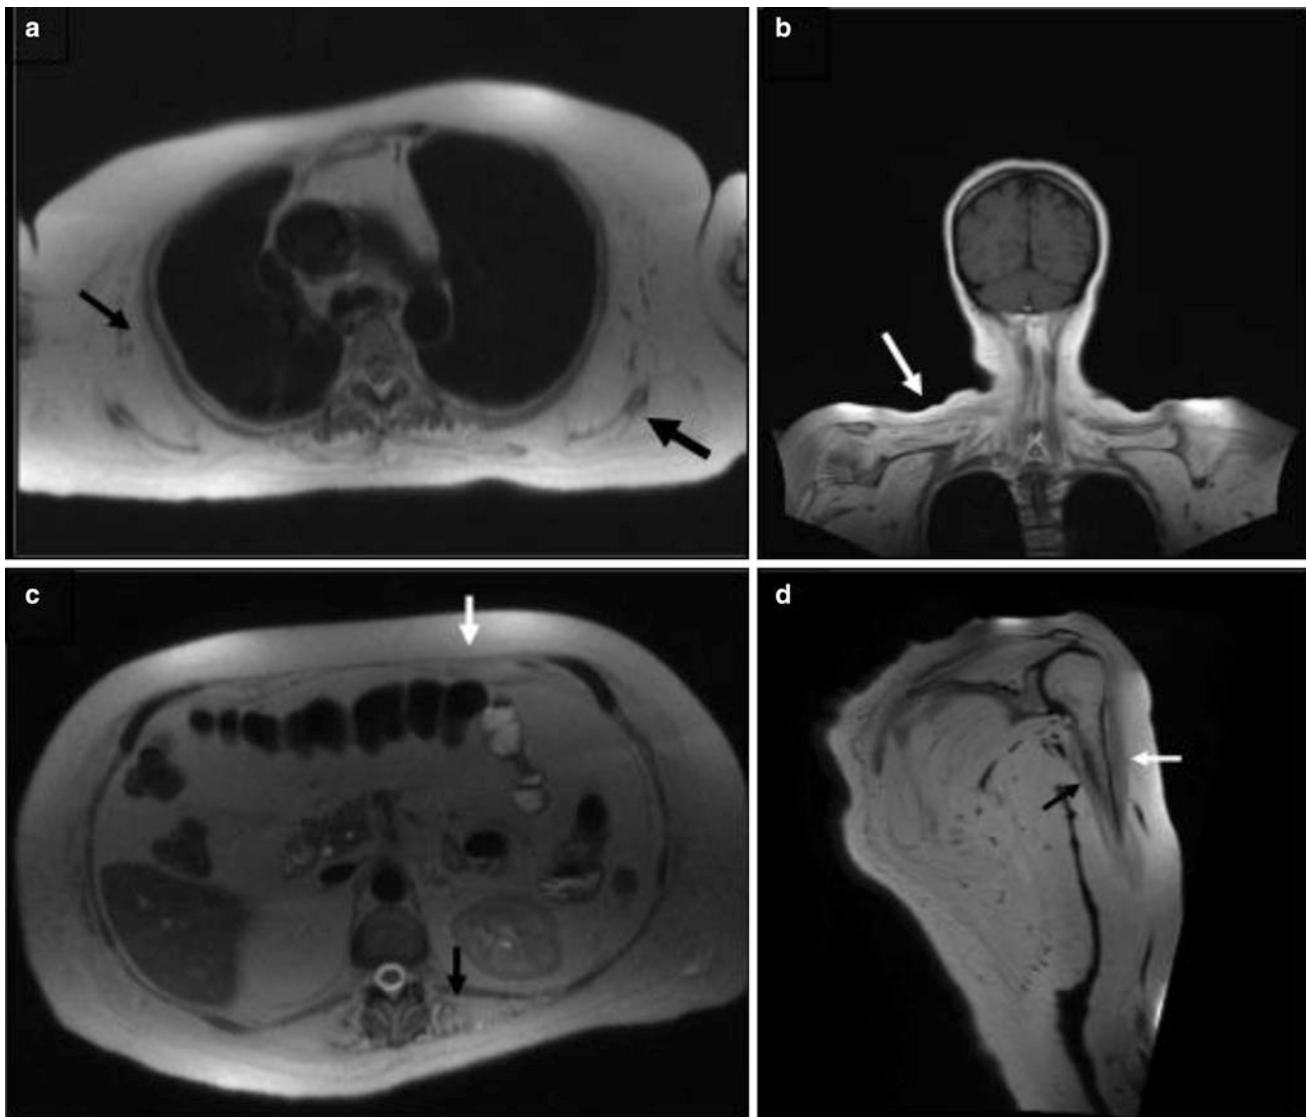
WB MRI demonstrates involvement of the muscles of the shoulder, the upper arm, and the trunk in a patient with myotilinopathy. Severe fatty degeneration (T1w) of the shoulder muscles (*thick*
